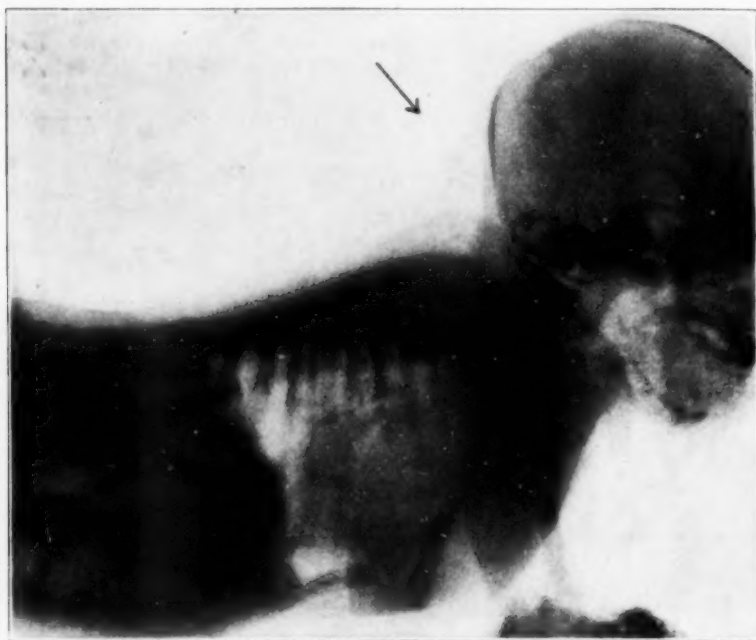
Roentgenogram, showing marked retroflexion of the head in the same patient as in figure 1.
